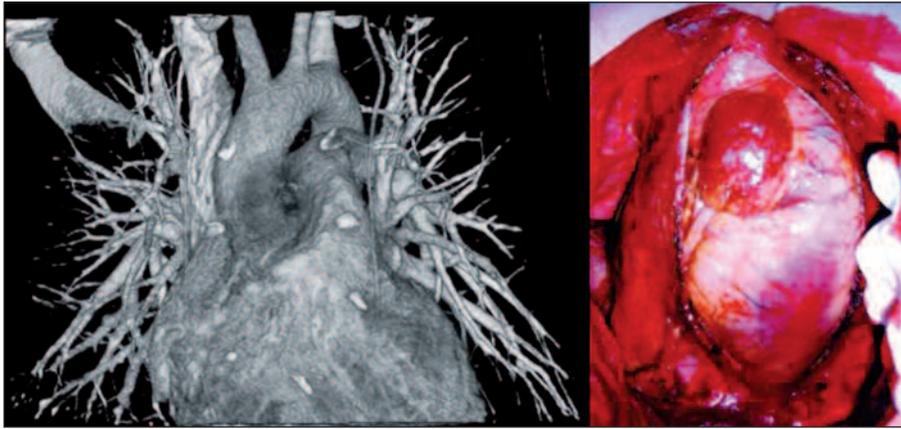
Dynamic CT angiography of the intrapericardial lesion that revealed no invasion to the wall of main pulmonary artery and ascending aorta and intraoperative view of the intrapericardial lesion.
